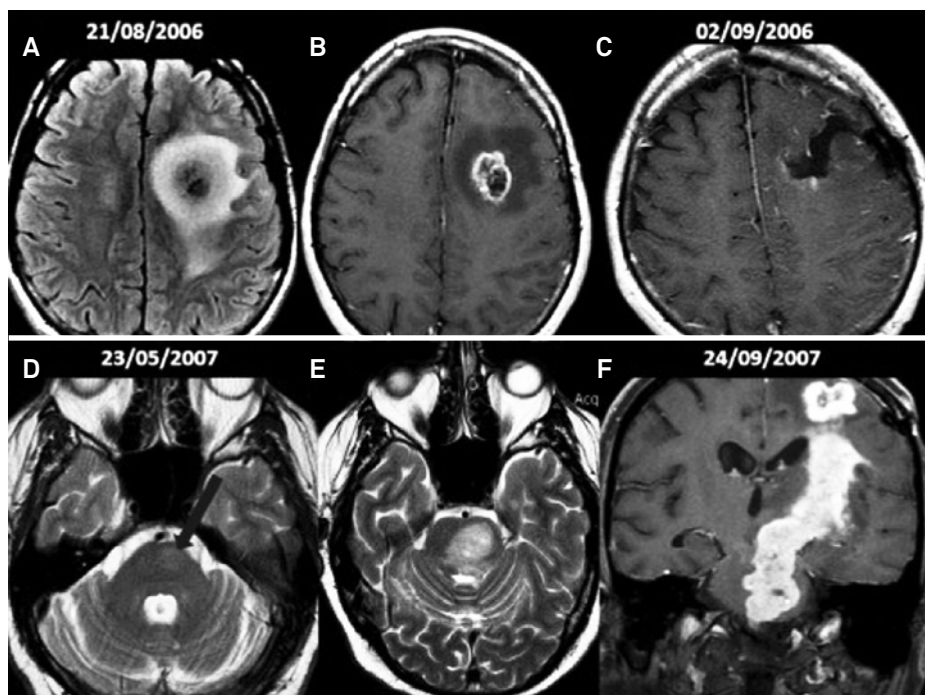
(A) axial FLAIR; (B) axial T1-weighted brain MRI disclosing an infiltrative lesion, suggesting a brain tumor. Note necrotic center and gadolinium enhancement, surrounded by vasogenic edema in the upper and middle frontal gyri of the left cerebral hemisphere; (C) axial T1-weighted brain MRI demonstrating postoperative imaging; (D) axial T2-weighted brain MRI showing hyperintense signal in the left portion of the paramedian pontine base, in the topography of the pyramidal tract; (E) axial T2-weighted brain MRI; (F) coronal T1-weighted brain MRI disclosing an infiltrative and neoplastic lesion, with a marked hyperintense signal throughout the left pyramidal tract, from the corona radiata to the pontine base.
